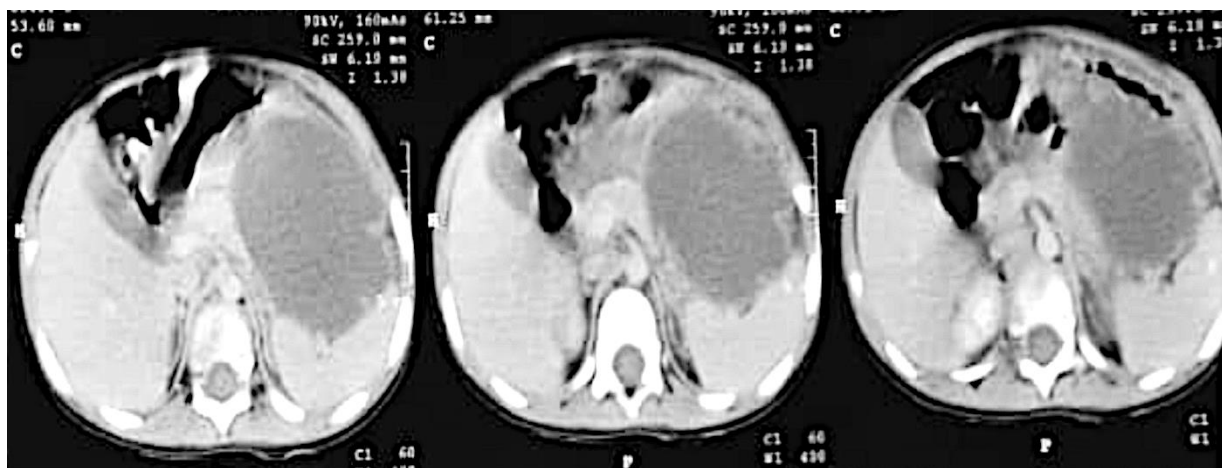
Axial CT scan of the abdomen showing fluid collection with immature wall cyst around the tail of pancreas indicates acute formation of cyst
